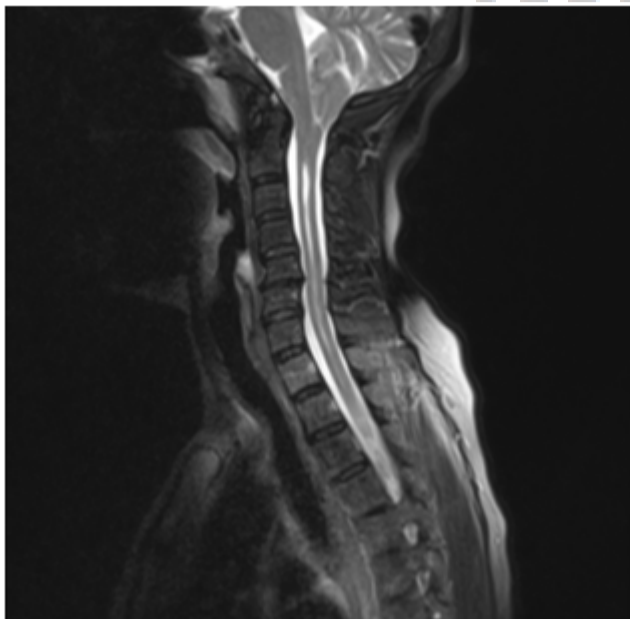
Saggital T2WI MRI image showing a case of cervical and thoracic spinal cord syrinx associated with ACM Type 1.
